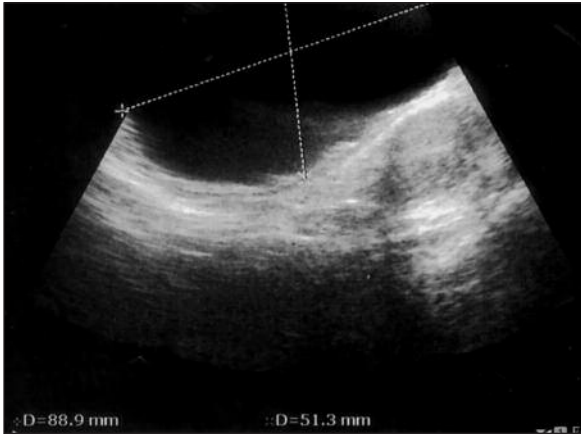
Ultrasonography of the mass (51.3 x 88.9 mm) which was anechoic surrounded by a tissue similar to bladder and filled with urine protruding to scrotum.
